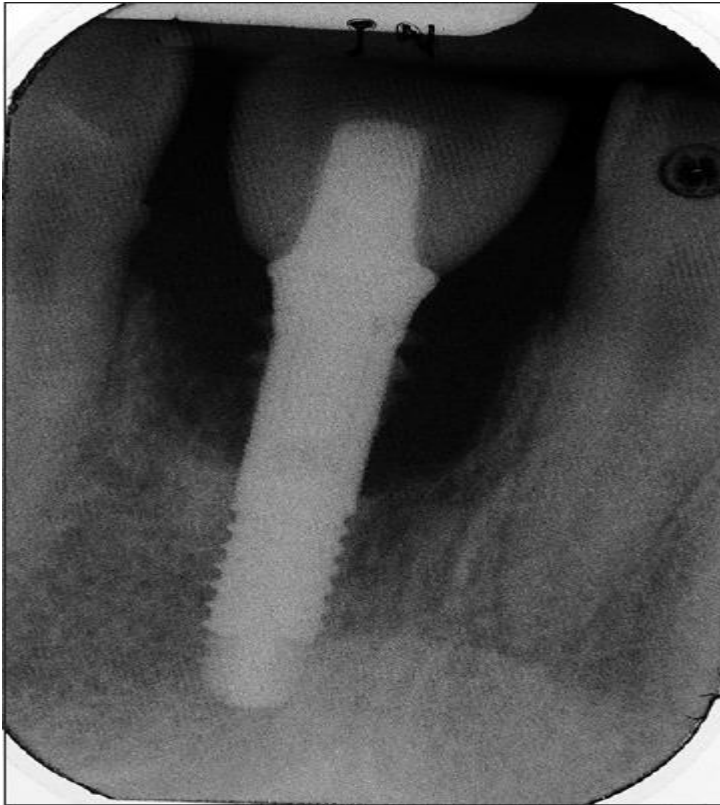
Radiographic picture showing significant bone loss around the implant
